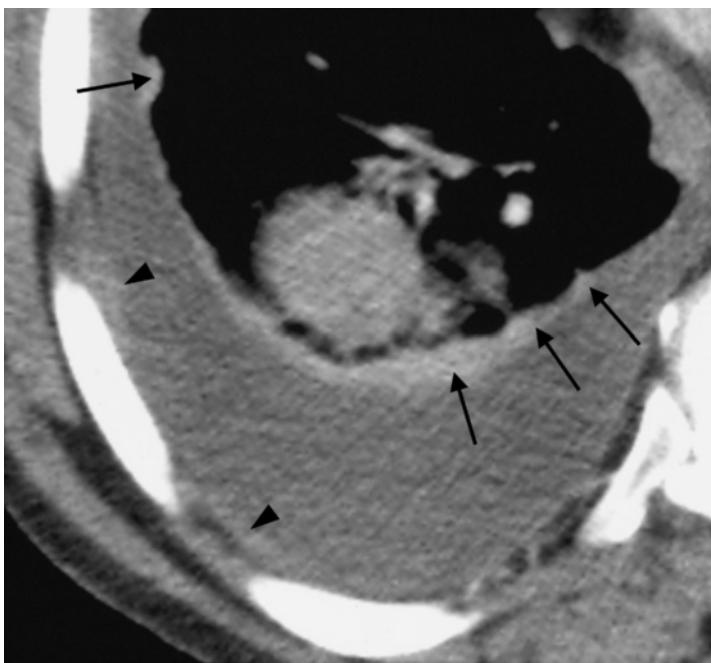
Pleural effusion on the right side in pleural metastatic disease. CT shows a clearly nodular visceral pleura (black arrows) and faint thickening of the parietal pleura (black arrowheads).
